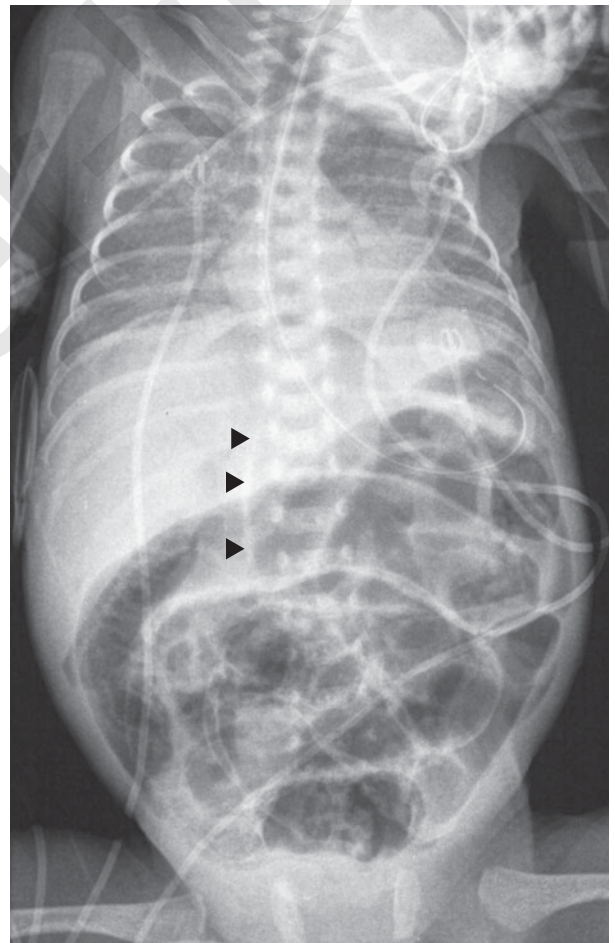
Supine chest and abdomen. Supine x-ray of the chest and abdomen in a premature neonate demonstrates abnormal increased lucency over the liver, with free intraperitoneal gas clearly outlining the falciform ligament (arrowheads). A decubitus x-ray is not required in this situation as the diagnosis of perforation is already made. Also evident is intramural gas in keeping with necrotizing enterocolitis and diffuse granular pulmonary parenchymal opacity with central air bronchograms, typical of surfactant deficiency syndrome.
